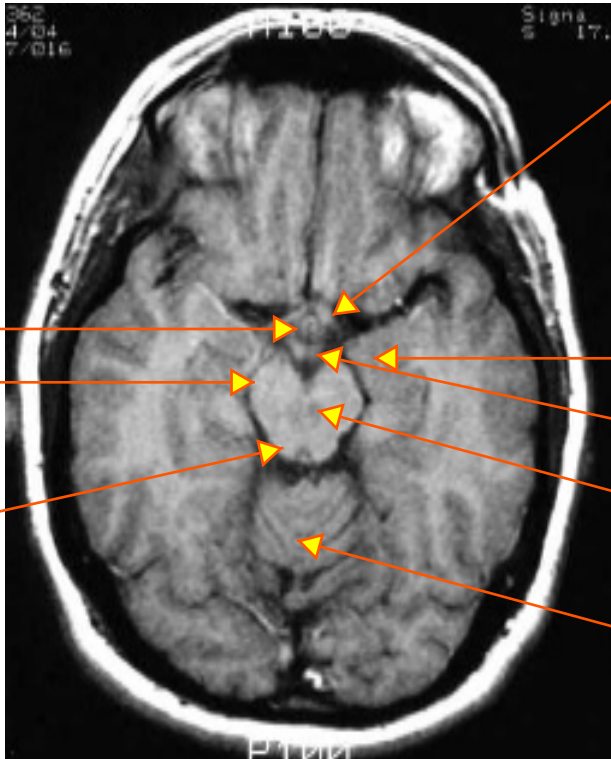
T1 Axial MRI. (From Rand Swenson
